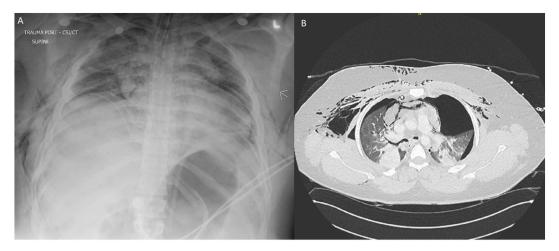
Chest radiograph (A) and CT scan (B) showing massive left pneumothorax with left pneumothorax with mediastinal shift, pneumomediastinum, and significant supraclavicular subcutaneous emphysema.
